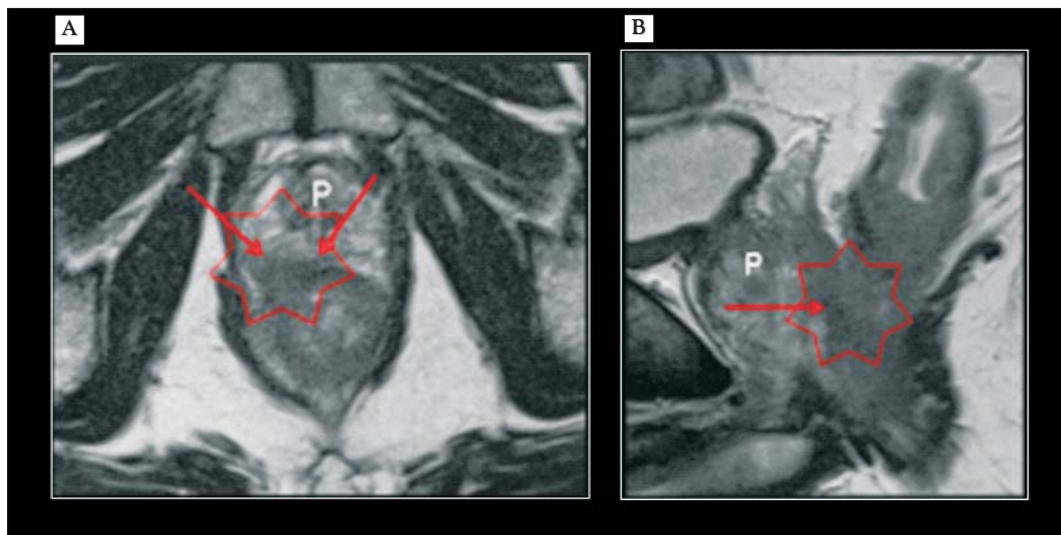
T4 stage MRI: (A) - sagittal, (B) - axial, presenting a T4 tumour which invades the prostate (P)
